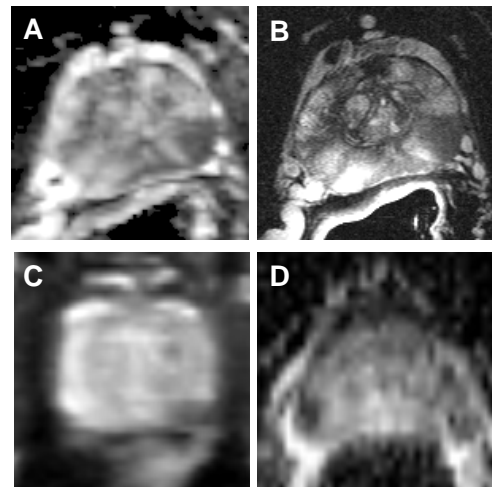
Diffusion MR image quality comparison. (A) ADC by optimized endo-rectal coil diffusion protocol, (B) corresponding T2w image, (C) ADC by optimized body coil diffusion protocol, and (D) ADC by non-optimized endo-rectal coil diffusion protocol.
